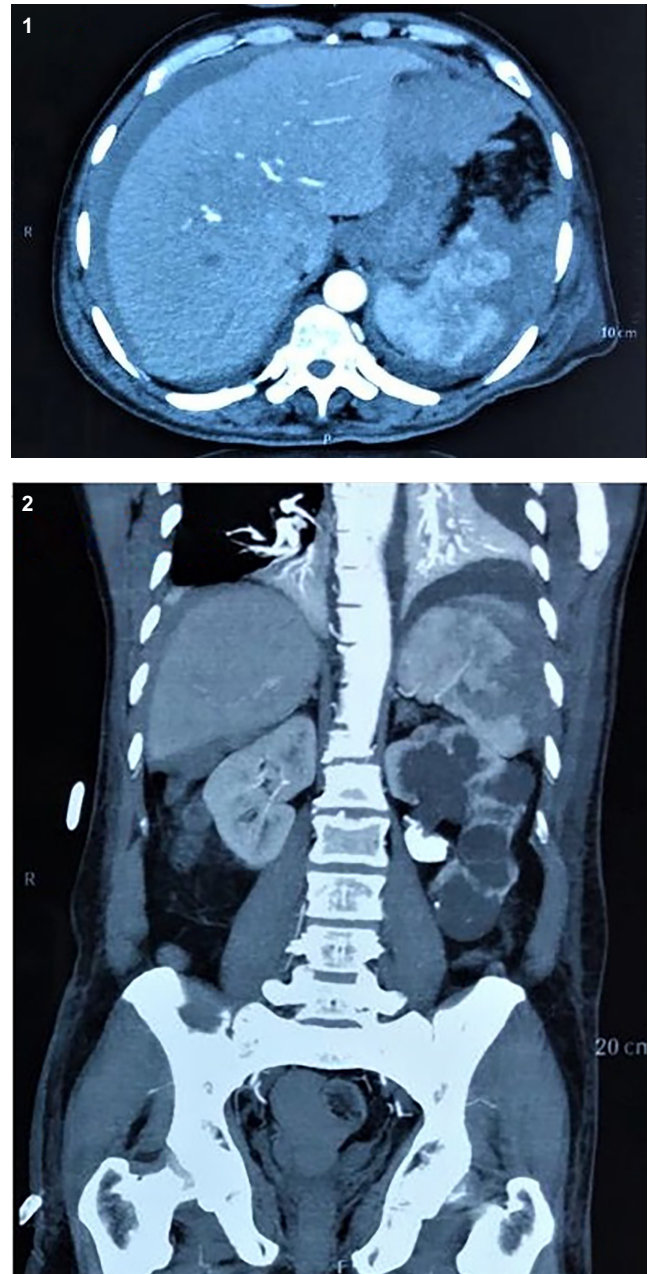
Abdominal computed tomography reveals splenic laceration, ruptured capsule, and peri-splenic hematoma (approx. 7.2 cm) (1) associated with intraperitoneal hemorrhage (2).
